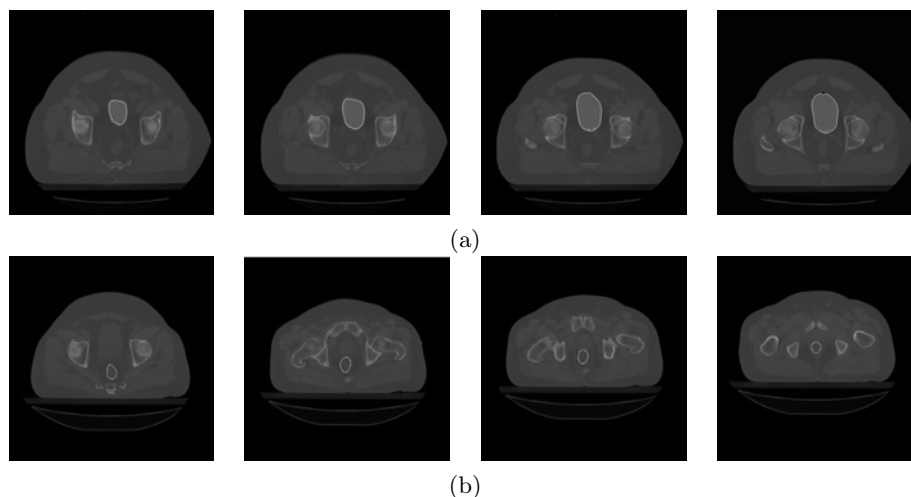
Geodesic active contour and region (GAR) model segmentation applied to ROIs in CT images of the pelvic area for radiotherapy treatment planning (RTP). (a) Bladder segmentation; (b) Rectum segmentation
